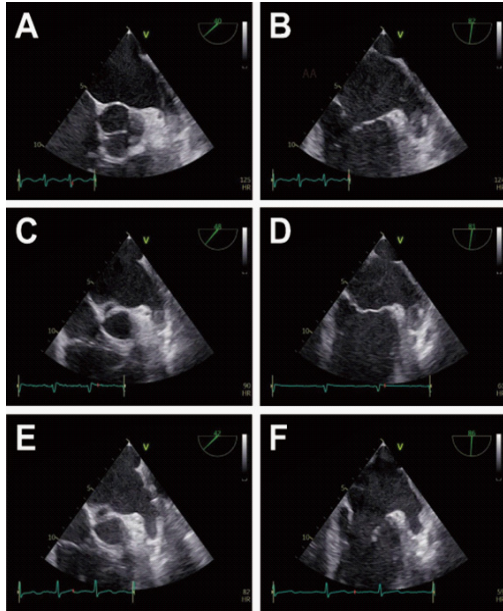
Sequential transesophageal echocardiography images of left atrial appendage thrombus. Panels A and B are 7 days, Panels C and D are 14 days, Panels E and F are 17 days after edoxaban administration, respectively.
